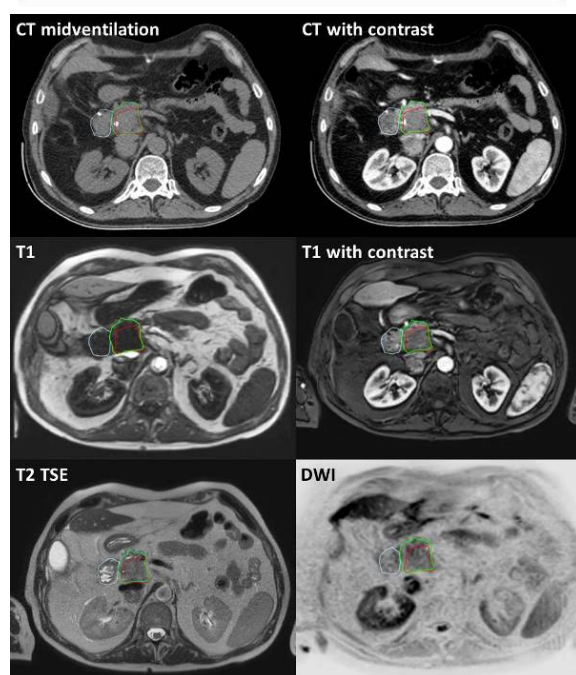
Contouring with the aid of MRI and CT. Red: GTV. Green: pancreatic head. Blue: duodenum.
